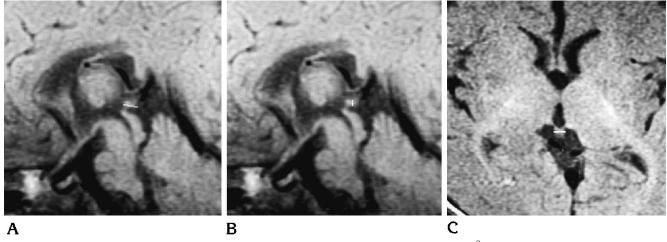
MR images of the pineal gland in a 3-month-old girl with hypoxia (volume,  $16.9 \text{ mm}^3$ ). A, The length of the pineal gland (*white line*) is 4.5 mm on T1-weighted sagittal image. B, The height of the pineal gland (*white line*) is 2.5 mm on T1-weighted sagittal image. C, The width of the pineal gland (*white line*) is 3 mm on T1-weighted axial image.
